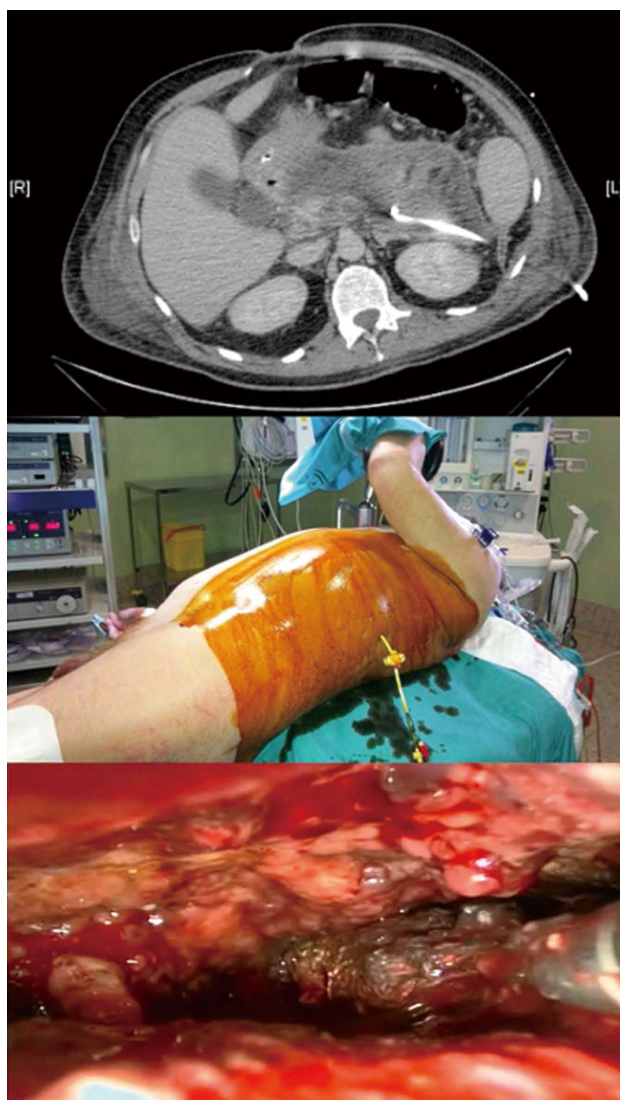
Video-assisted retroperitoneal debridement: Computed tomography scan with percutaneous drainage into an infected pancreatic necrosis (above); patient's position for necrosectomy (middle); endoscopic view of necrotic pancreatic tissue (below).
